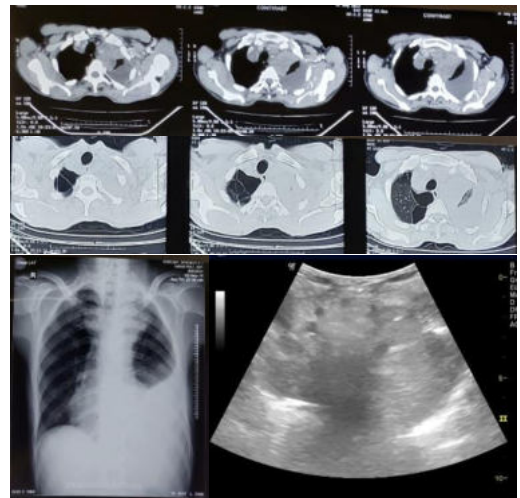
CECT Thorax shows heterogeneously enhancing soft tissue density lesion in the apical region of left hemithorax, broadly based to the apical and mediastinal pleura compresses the adjacent lung. Massive left sided pleural effusion causing complete collapse of lower lobe and inferior segment of lingular lobe with right sided mediastinal and tracheal shift . Necrotic mediastinal lymph nodes. Features s/o pleural malignancy? Mesothelioma. Chest radiograph shows mass lesion in left lung apex with left sided pleural effusion. Sonography shows mass lesion in left apex .
